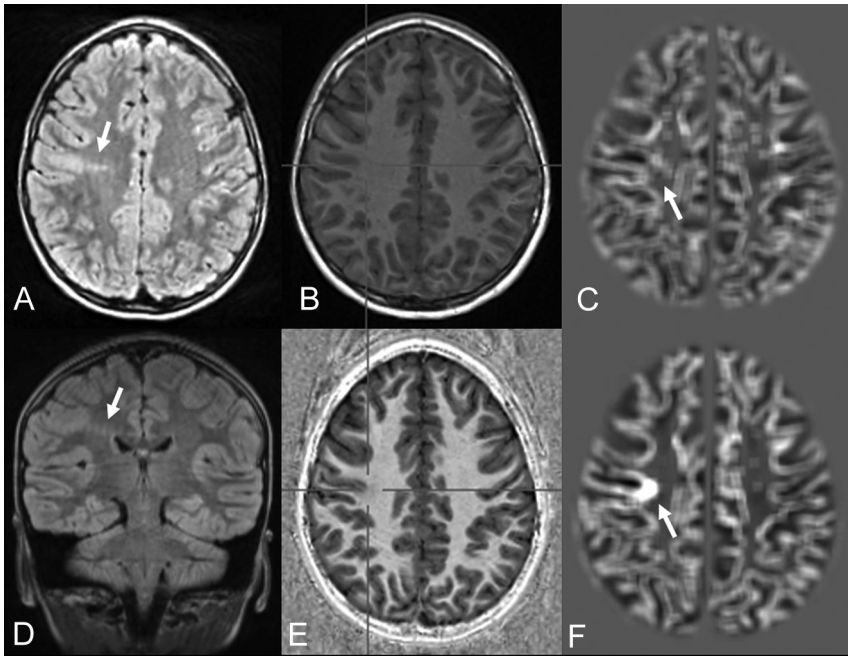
FCD with the transmantle sign of the right precentral gyrus in a 7-year-old girl with seizures (patient 18). Despite movement artifacts, the lesion is clearly visible on FLAIR (A and D) and MP2RAGE-based junction images (F). In an MPRAGE-based junction image (C) for comparison, the lesion is not clearly distinguishable. Strong T1WI contrast is seen in a uniform MP2RAGE image (E) compared with MPRAGE (B).
